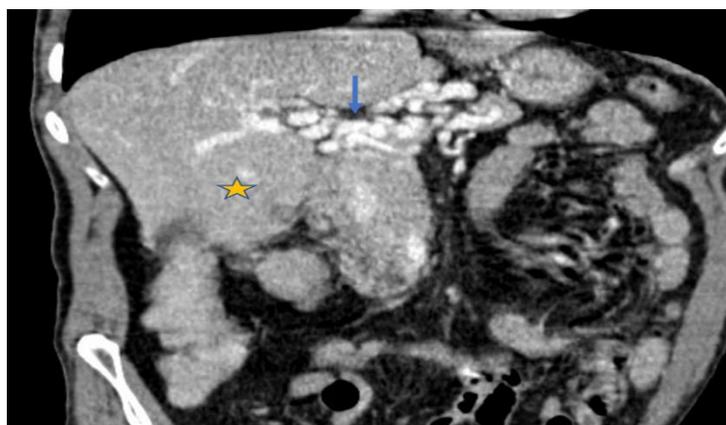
Coronal CT scan, portal phase: replacement of the portal vein by multiple serpiginous vascular structures compatible with a portal cavernoma (blue arrow). It was associated with a hypertrophy of the segment IV (orange star).
